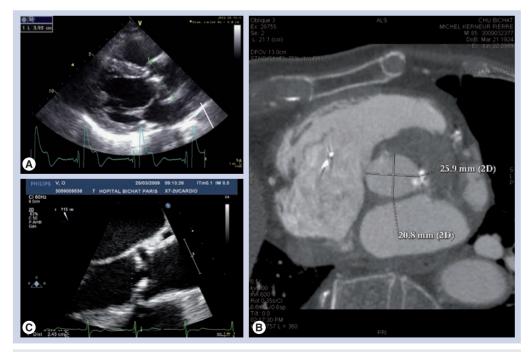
Multimodal assessment of aortic annulus diameter. (A) Transthoracic echocardiography: measurement of the annulus diameter. (B) Transesophageal echocardiography: measurement of annulus diameter, defined by the distance from hinge point to hinge point. (C) Multislice computed tomography, showing the oval shape of the aortic annulus, with a small and a large diameter.
